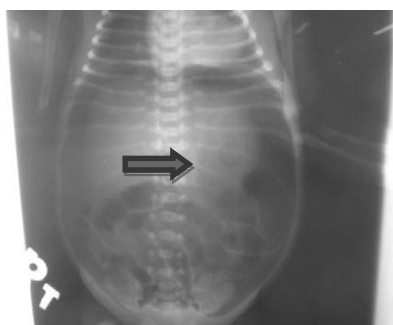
Plain abdominal x-ray: free air detected in abdominal cavity.
